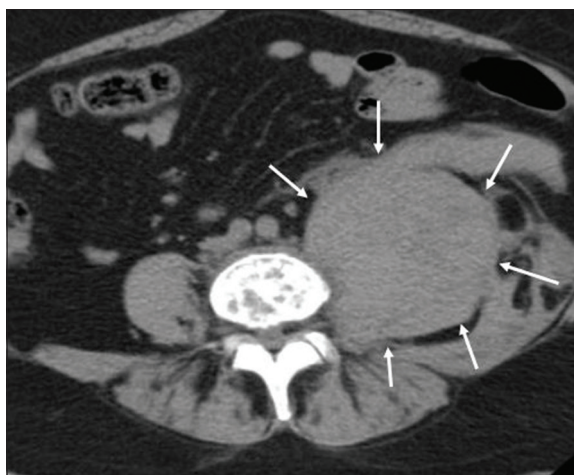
(Axial view) Computed tomography scan shows left side huge psoas hematoma (arrow).
